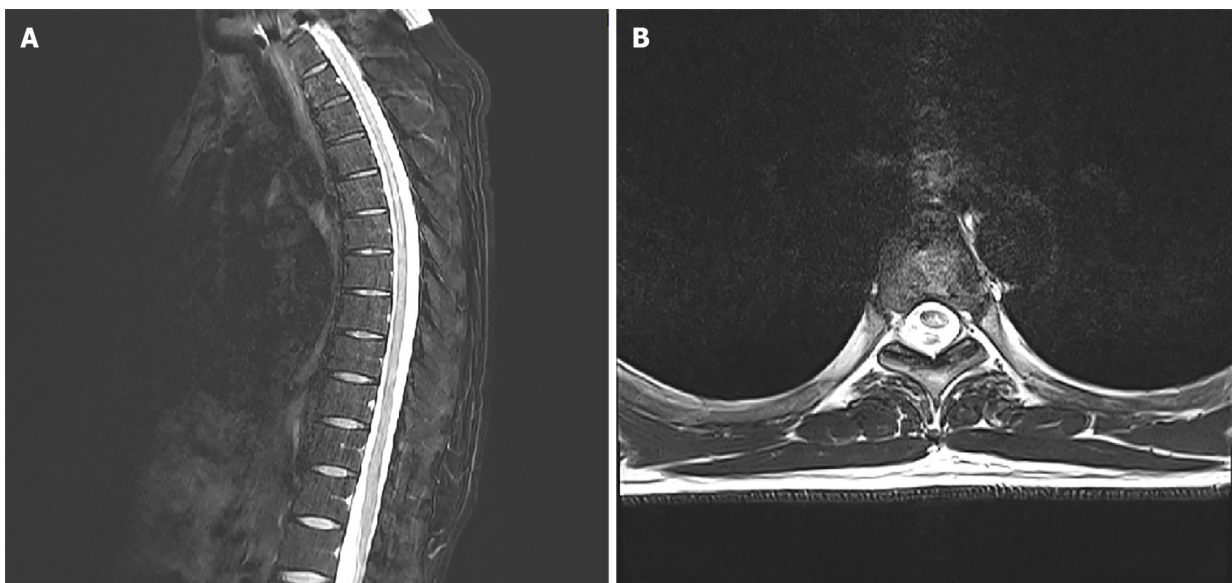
After 3 wk of antiviral and corticosteroid treatment, the high signal intensity had decreased slightly but had not resolved. A: Remaining high signal intensity at level T2-8 on a sagittal T2-weighted image; B: Level T5 on a coronal view.
